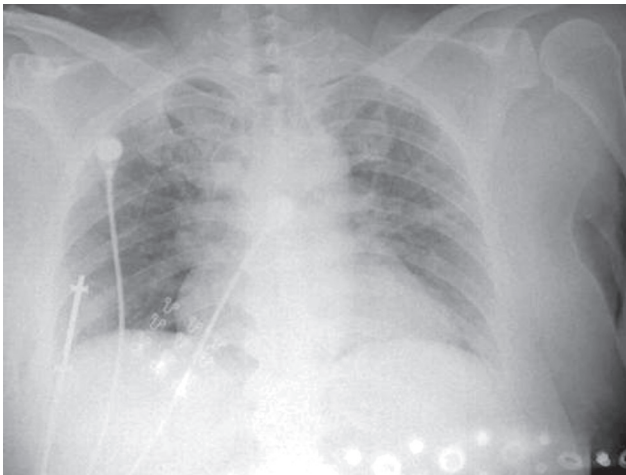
Chest roentgenogram of the patient. The straight radiopaque line in her right lower chest wall was interpreted as a wire of various monitors used in the emergency department.
